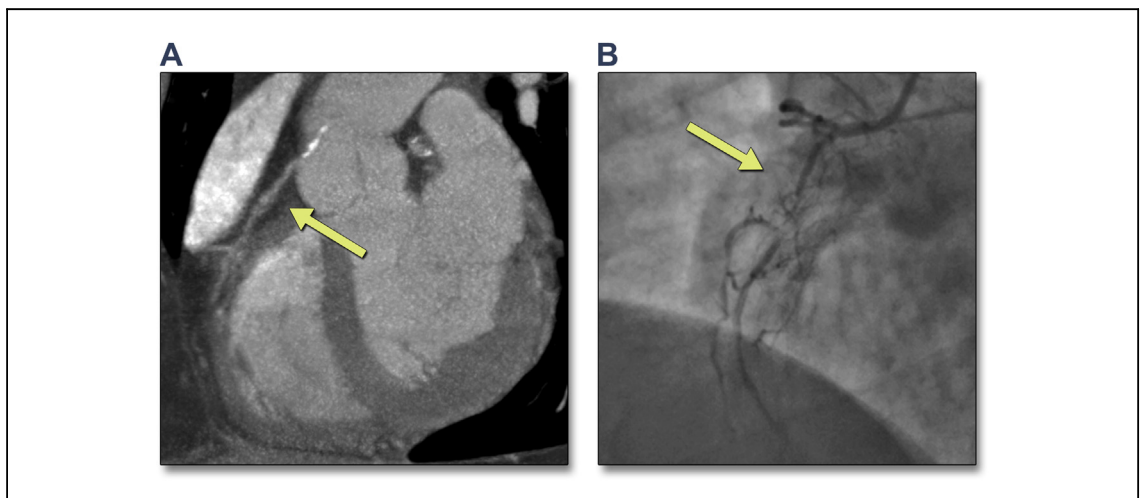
FN Diagnosis of Obstructive Coronary Artery Disease by CTA
